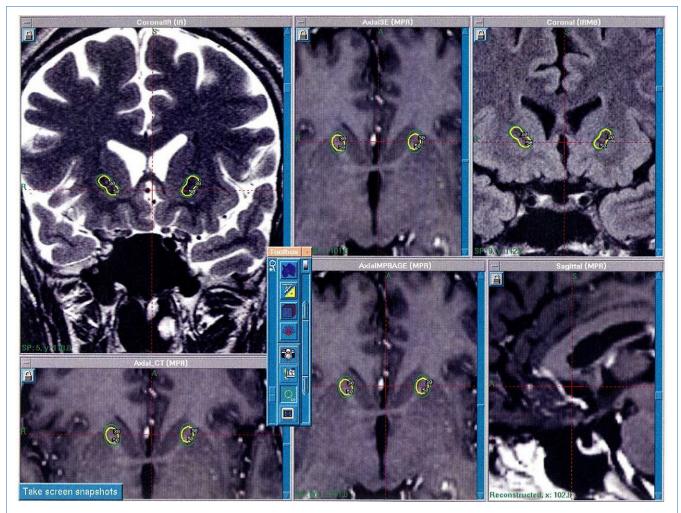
Magnetic resonance imaging axial and coronal gamma knife radiosurgical dose plan for anterior capsulotomy for a patient with severe intractable obsessive-compulsive disorder from the Gamma-Plan (Elekta
